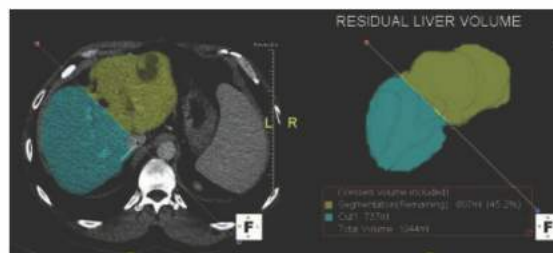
• CT volumetry for a right hepatectomy. The calculated liver remnant represents 45% of the liver volume.
